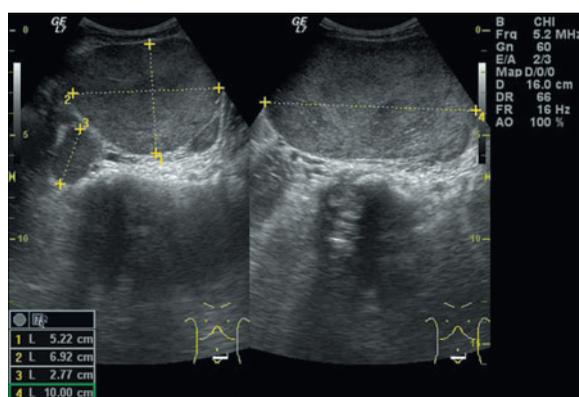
Girl WE. Transabdominal sonography of the pelvis – a well-delineated, solid, non-homogeneous tumor with linear hyperechogenic shadows. A second smaller tumor in anatomical placement of the right ovary. The uterus compressed, slightly displaced to the left.
